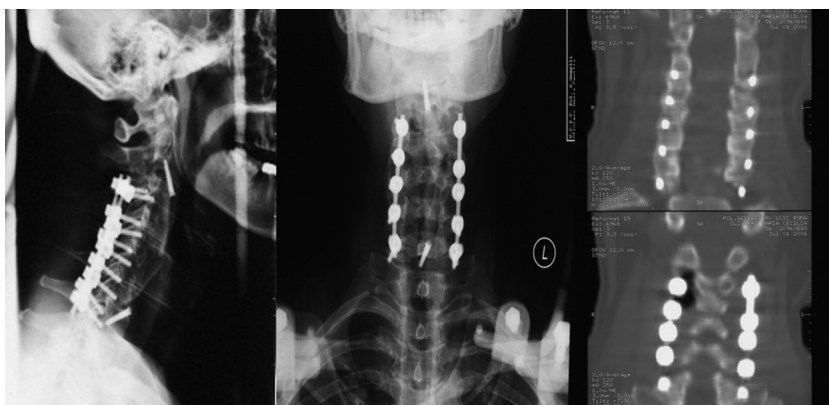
X-ray lateral (left) and AP (center) and CT scan coronal ((right) after third surgery “one stage combined” an anterior decompression with fusion along with posterior instrumentation with C3–C7 lateral masses screws and rods. De Puy Spine USA) was performed.
